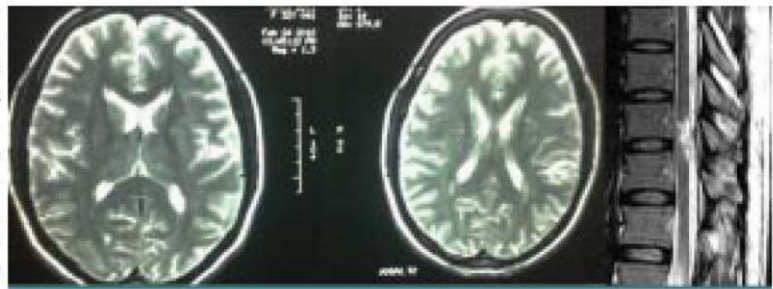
MRI brain and dorsal spine 3 months after the onset of illness
